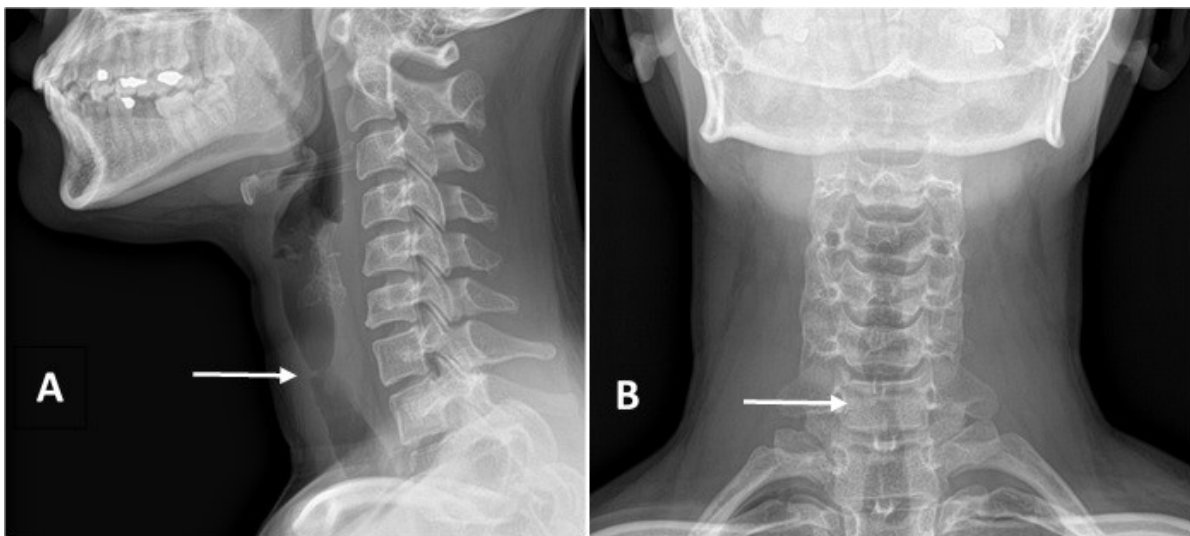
Soft tissue neck radiograph; lateral (A) and anteroposterior (B) view showed tracheal stenosis (arrow) at the level of 7th cervical vertebra (C7), with the tracheal structure in midline position and the upper airway appeared patent.
